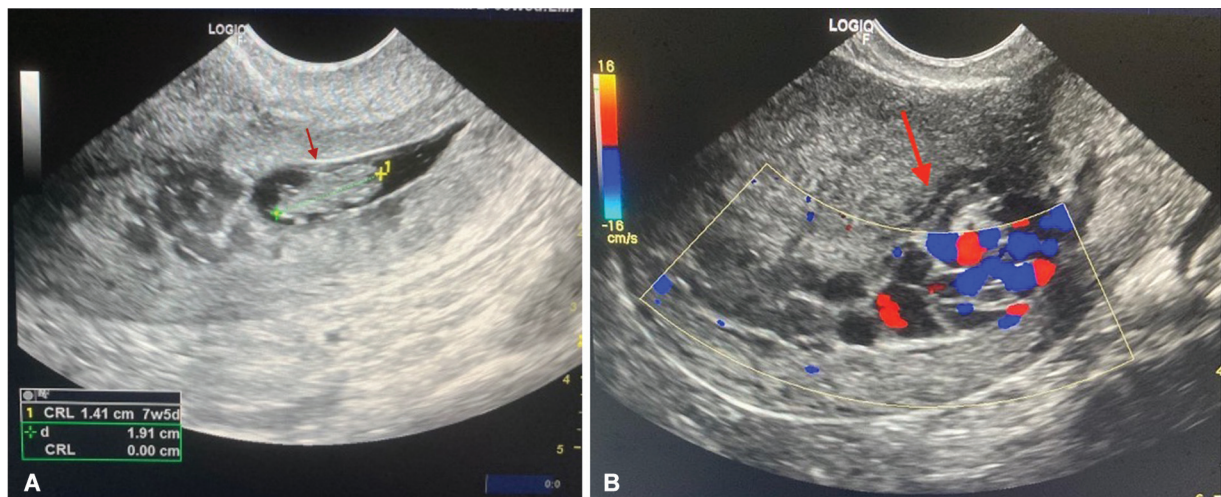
(A) An antenatal transvaginal ultrasound revealed a single irregular gestational sac in the cervical canal below the internal os, (B) with prominent surrounding vascularity giving a hypervascular trophoblastic ring.
